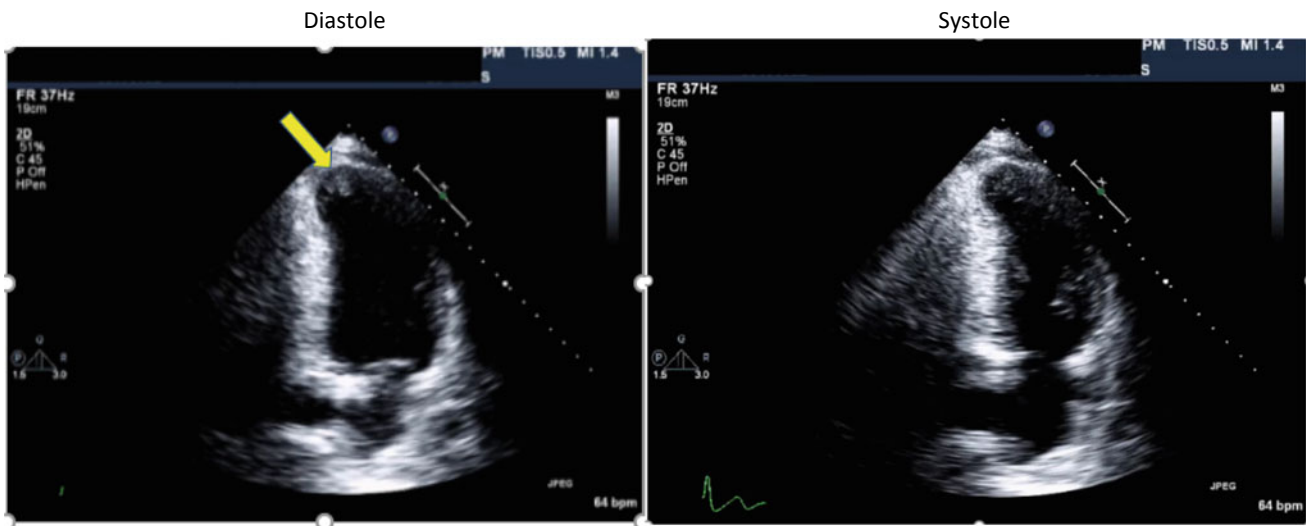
Echocardiogram with apical mass (arrow) and regional wall motion abnormality
